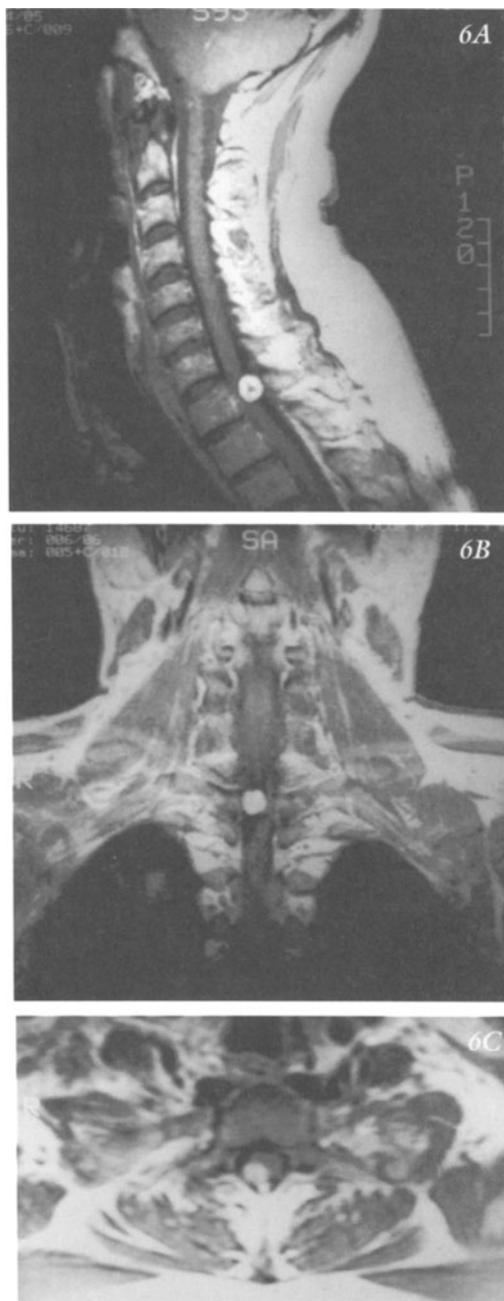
Schwannoma with compression of spinal cord. MRI with contrast enhancement. A) Sagittal section-midline. B) Coronal section between posterior arches and dorsal surface of spinal cord. C) Transverse section-T1-vertebral level.
